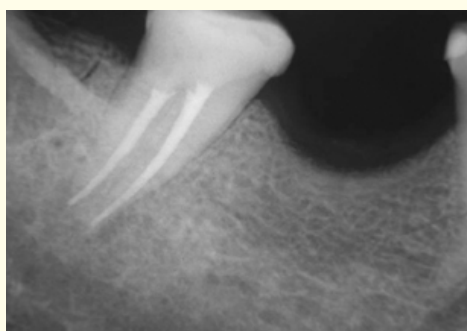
Initial (preoperative) radiograph.
